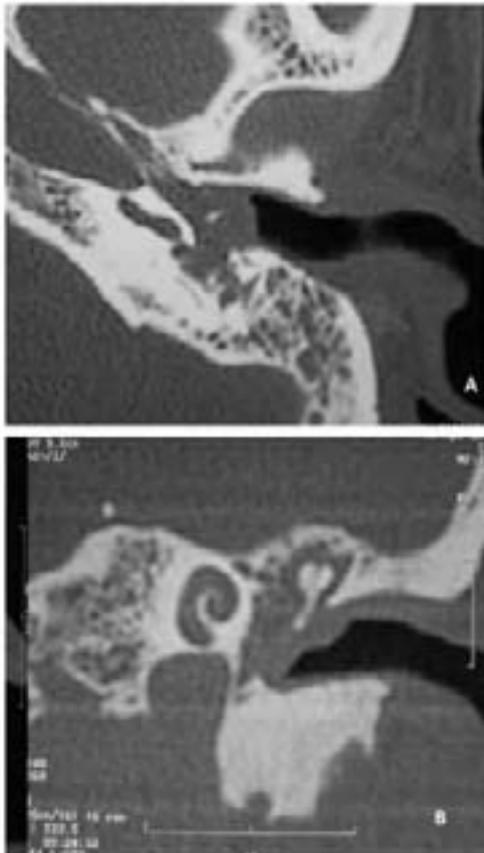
Axial (A) and coronal (B) CT scan of the left temporal bone showing thickening of the mucosa of the mastoid cavity and middle ear without bone destruction.
